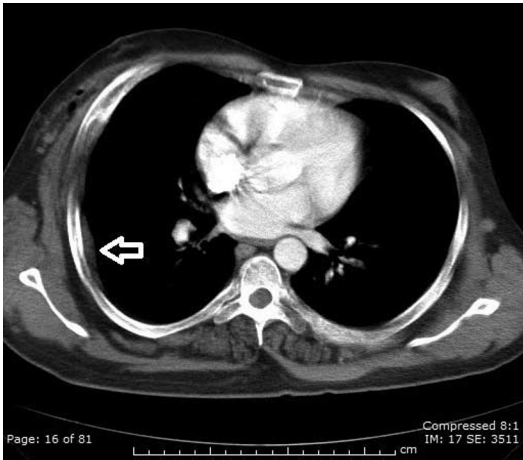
Proteus Syndrome in a 26-year-old male. Axial CT. Note extrapleural lesion in the peripheral right lung (white open arrow), and soft-tissue infiltration of the right anterior lateral chest wall.
